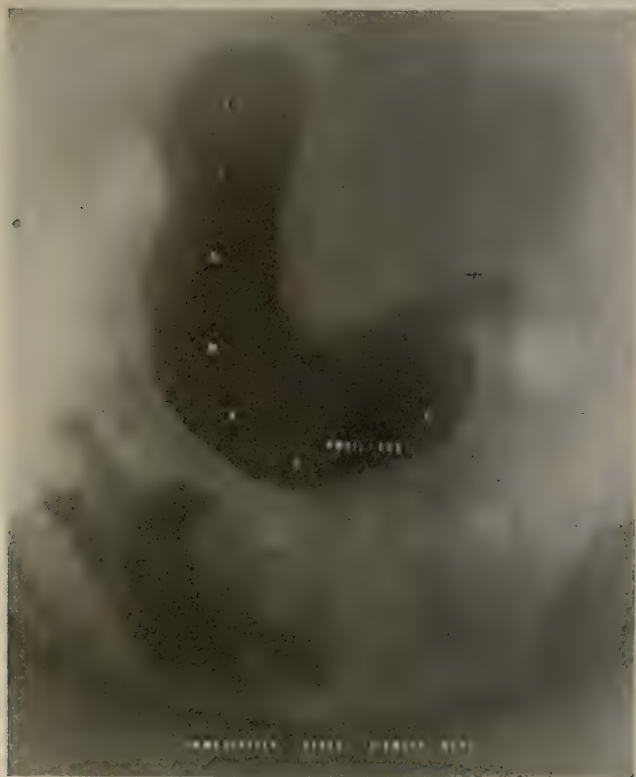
At + a large bismuth deposit in the duodenum showing it dilated; probably obstruction from adhesions from gall-bladder. No stones visible in radiograph. *Indirect method.* Diagnosis: Gall-stones, adhesions and chronic pancreatitis. Demonstrated correct at operation by John Erdmann.
